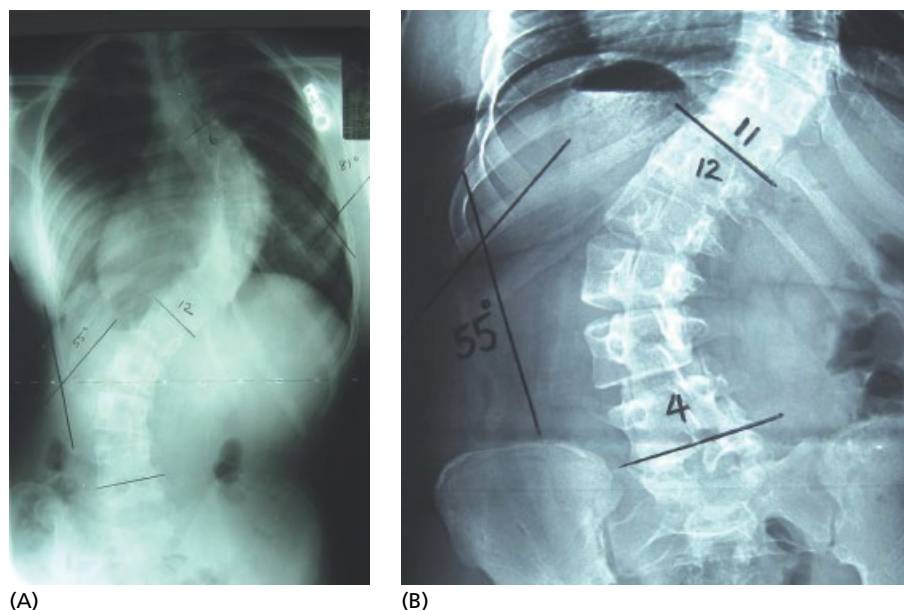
Radiographs showing the determination of the Cobb angle.
